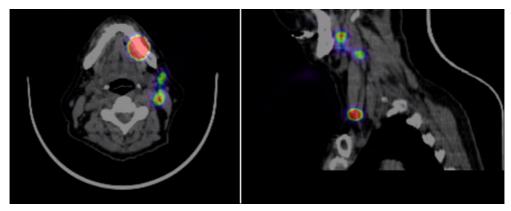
SPECT/CT of sentinel nodes (picture by Heikki Irjala).
